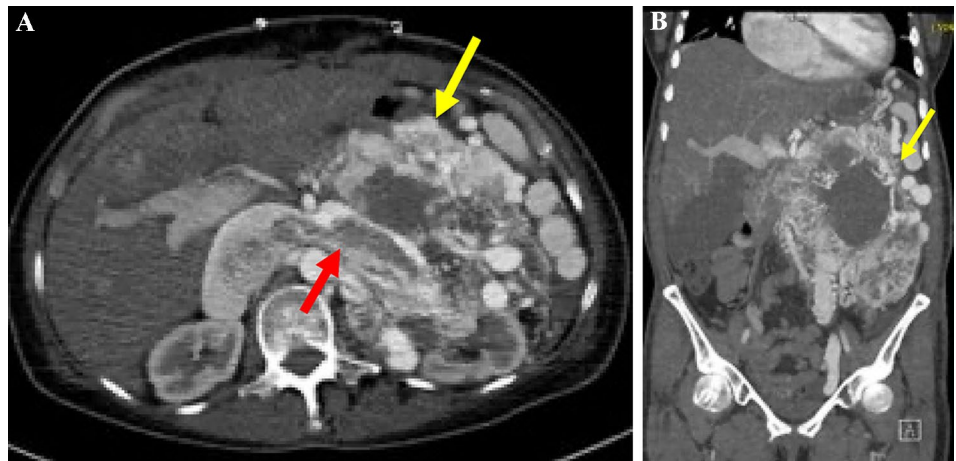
Infiltrating left adrenal pheochromocytoma in a patient who presented with neck bruit. Axial (A) and coronal (B) CT images show a 19.5 cm infiltrating left adrenal pheochromocytoma (yellow arrow) with intense peripheral enhancement up to 219 HU and central necrosis invading the left renal vein and IVC (red arrow)
